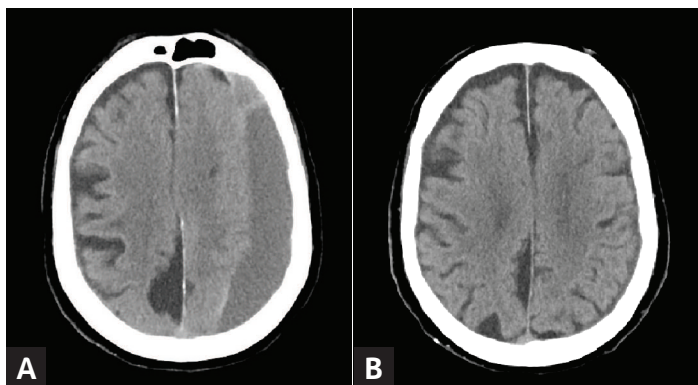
MMA embolization in a 94-year-old gentleman. Preoperative axial CT revealed a large chronic subdural hematoma. The patient underwent MMA embolization with no further surgical intervention. Panel (B) demonstrates a follow-up axial CT 3 months later, where no residual hematoma is observed.
